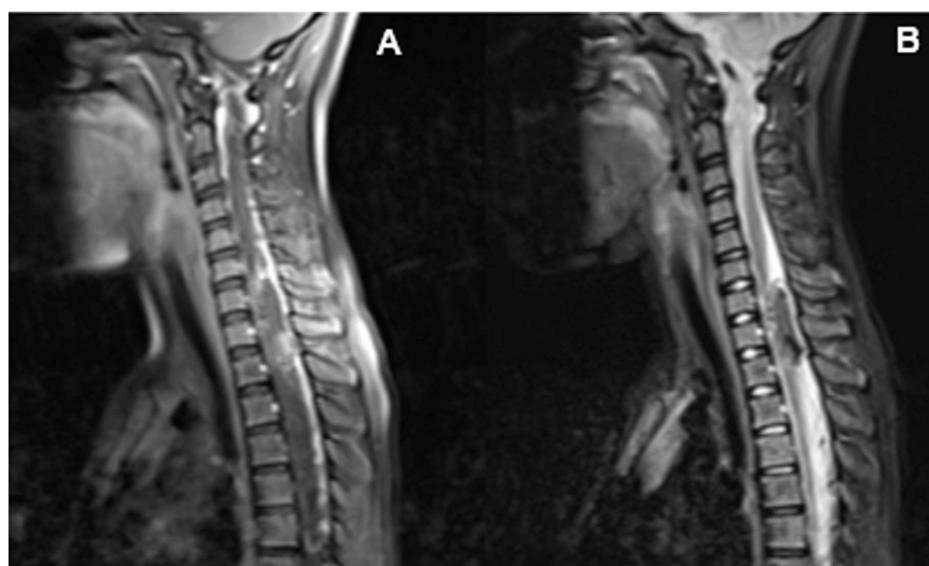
Case 2. Cervical hemorrhagic extradural cavernous hemangioma. Preoperative MRI. (A) Sagittal section, C+ T1WI showing a non-enhanced iso-hyperintense epidural mass compressing the thecal sac from behind. Note the edema of the paravertebral soft tissues and the straightening of the cervical spine from antalgic contracture. (B) Sagittal section, T2WI showing hypointense signal of the lesion.
